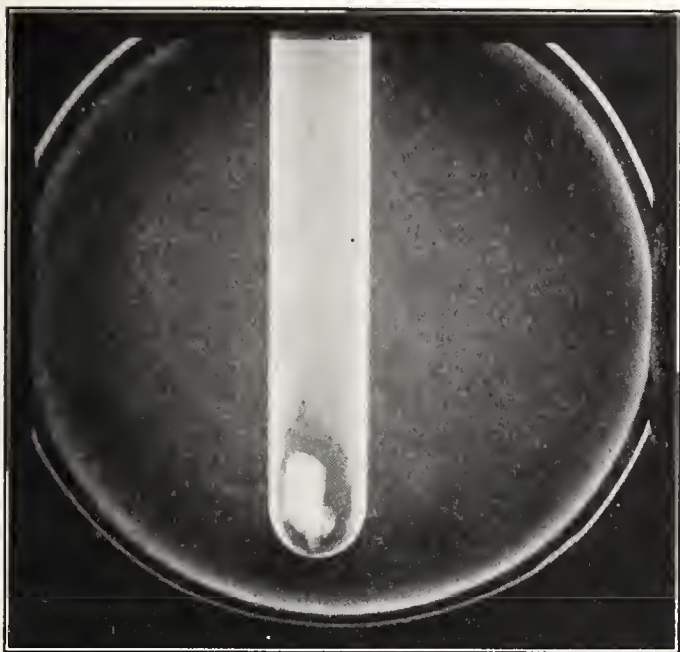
(Case 3).—Large ureteral stone in tube and beaker of urine, which did not cast an x-ray shadow in patient.
